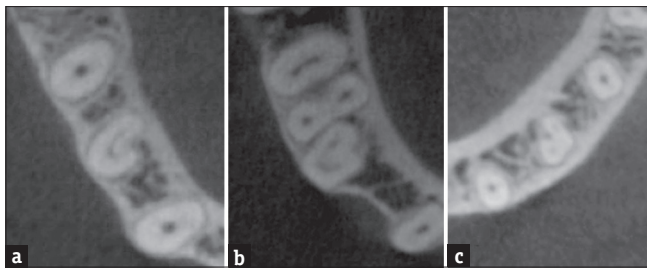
Example of axial cone-beam computed tomography (CBCT) sections for mandibular premolars in middle level: a) shows type C1; b) shows type C2; c) shows type C3
